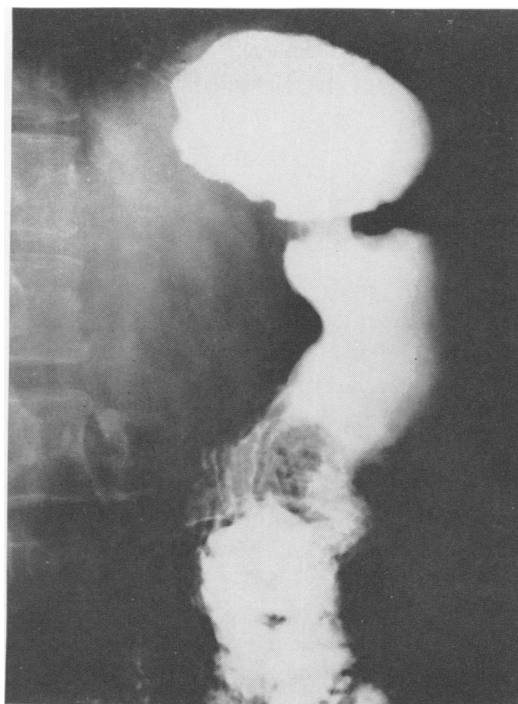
Radiograph demonstrating jejuno-gastric intussusception in Case 2.
